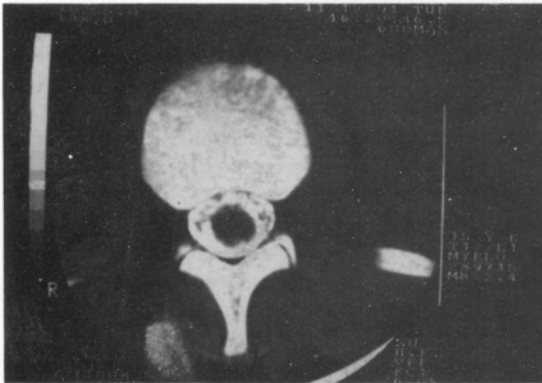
The myelo CT scans of the patient at the level of Th12 vertebrae
